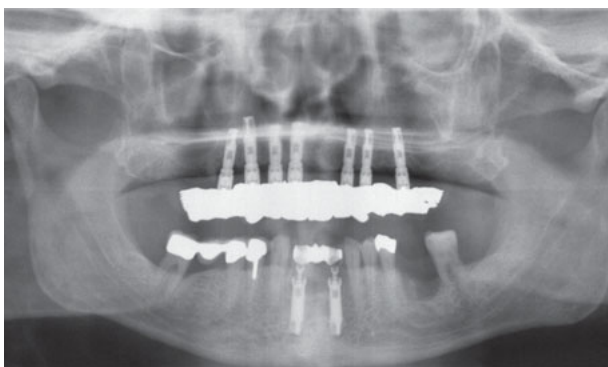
Follow-up panoramic radiograph.
